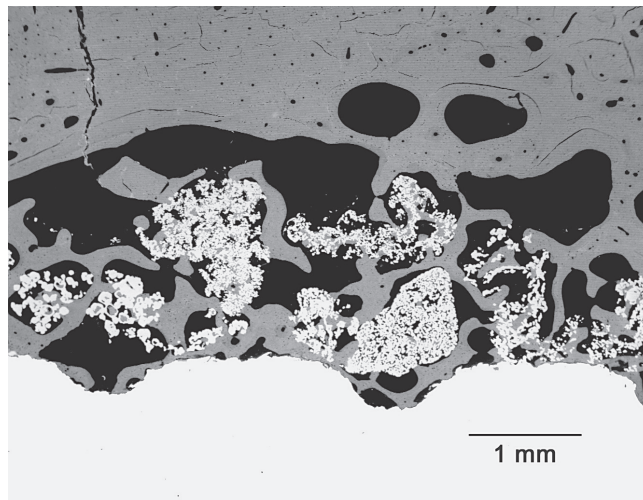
Contact radiograph of a cross section showing bone formation within the mantle of granules and direct contact between bone and prosthesis
